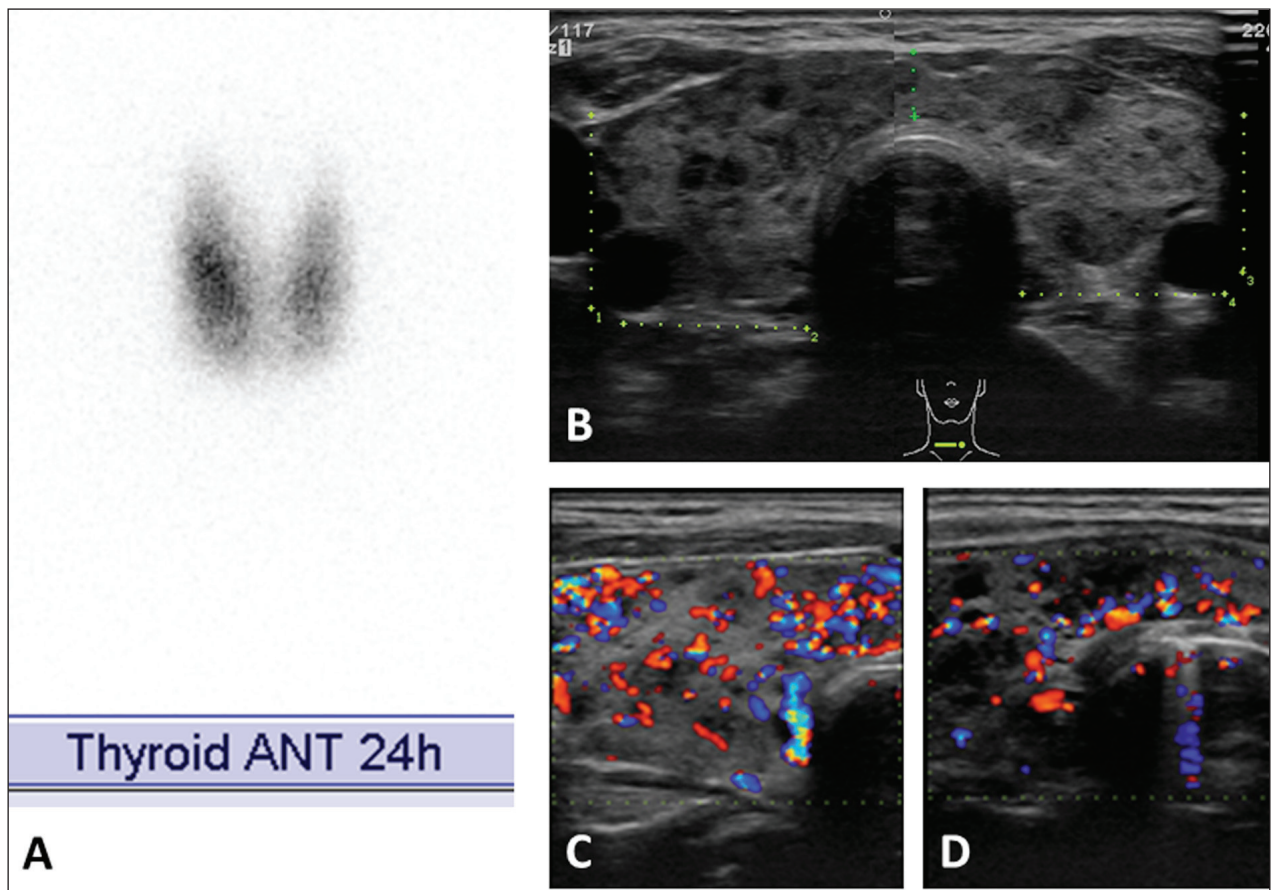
High ^{123}I uptake (76.3% in 24h) led us to diagnose comorbid Graves' disease (A). The ultrasonography revealed the enlargement of thyroid gland with heterogeneous echotexture (B) and hypervascular pattern in the color Doppler imaging (C, D)
